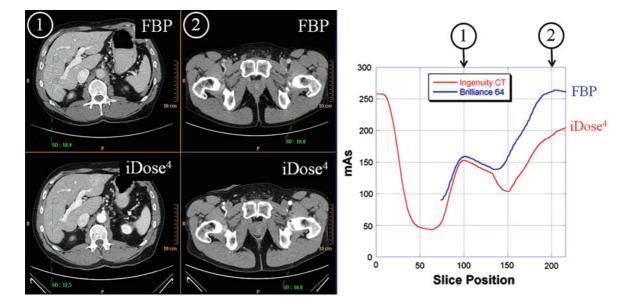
Left upper raw Acquisition performed on the Brilliance 64-Channel scanner and reconstructed with FBP. The aquisition was performed with DoseRight Z-DOM without liver image quality boosting (see Sect. 3.2). In the liver parenchyma, we measure the noise as SD = 18.4 HU at an exposure = 159 mAs. In the pelvis, we measure SD = 10.8 HU at an exposure = 261 mAs. Left lower raw Acquisition performed on the Ingenuity CT scanner and reconstructed with iDose⁴ on the same patient at a later date for an oncology follow-up. The acquisition was performed with DoseRight Z-DOM with liver image quality boosting. All other acquisition parameters were identical compared to the acquisition performed on the Brilliance 64-Channel scanner. In the liver parenchyma, we measure the noise as SD = 12.5 HU at an exposure = 152 mAs. In the pelvis, we measure SD = 10.8 HU at an exposure = 191 mAs. Right:
